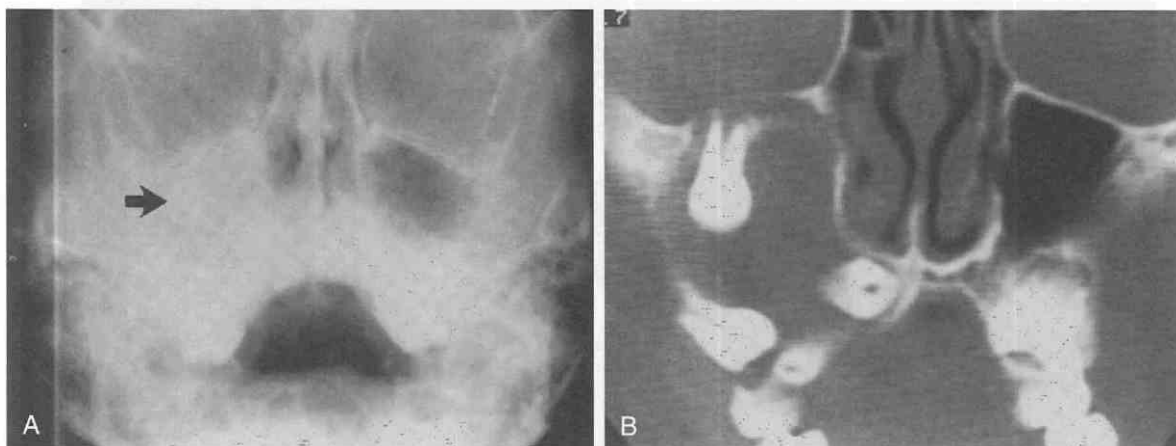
Odontogenic mass. On the Waters view of the paranasal sinuses, a teardrop-shaped density was identified in the right maxillary sinus (A, arrow). The accompanying coronal CT image (B) revealed an expansile mass containing multiple teeth.
